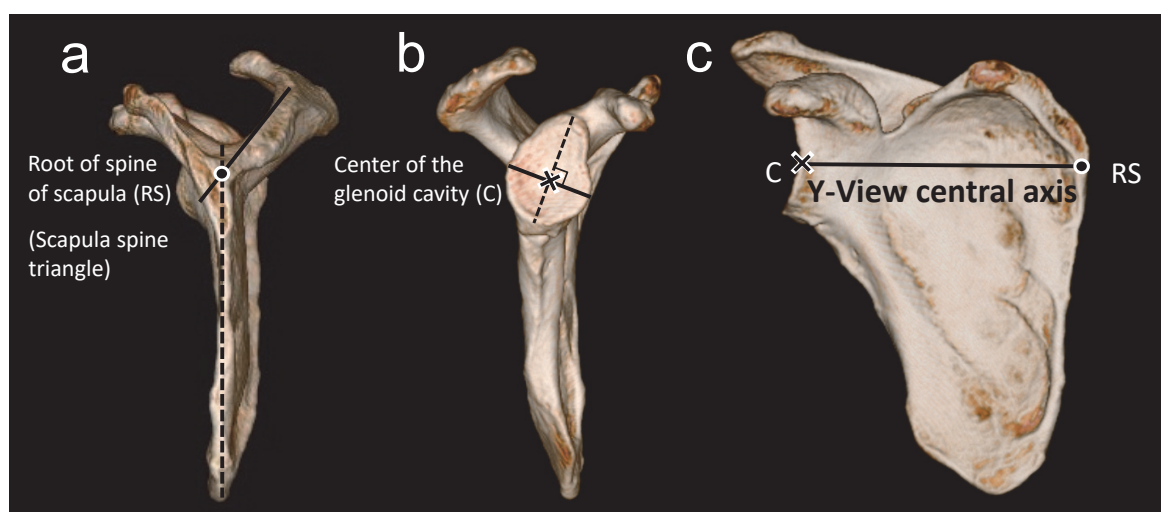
Position of point of incidence of the X-ray (root point of the spine of the scapula) and the point of injection (center of the glenoid cavity) and The Y-View central axis
